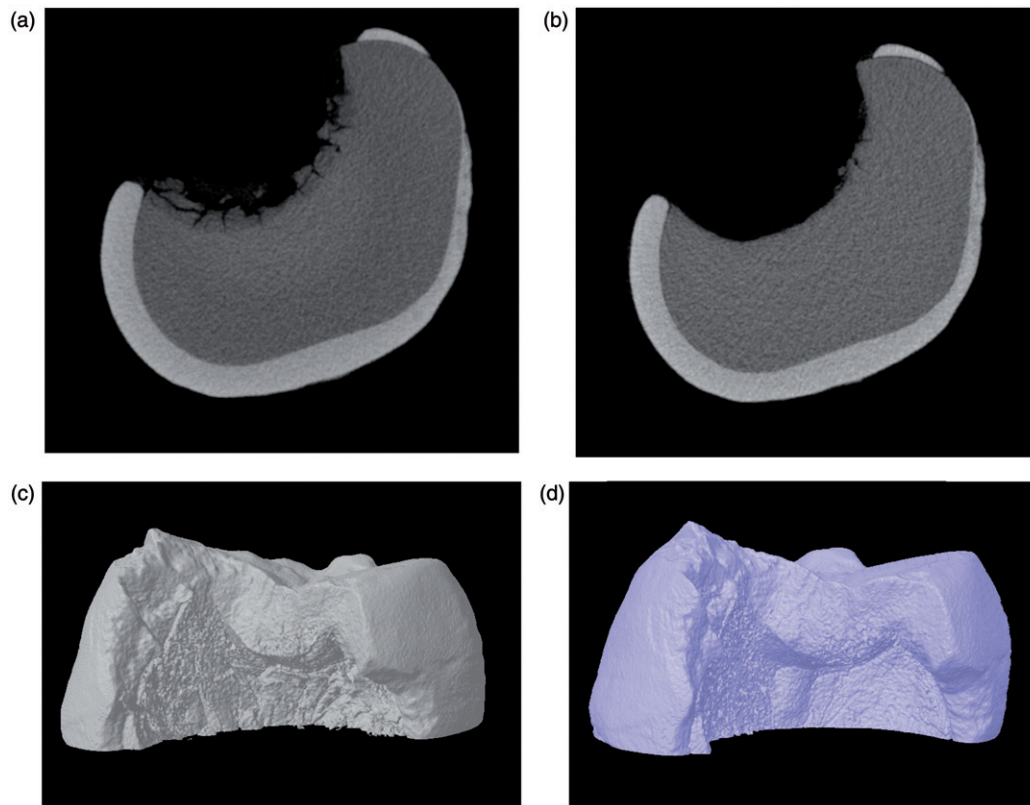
X-ray microtomography images of molars excavated with chemomechanical caries removal agents; two-dimensional image (a) before and (b) after excavation and three-dimensional image (c) before and (d) after excavation.
